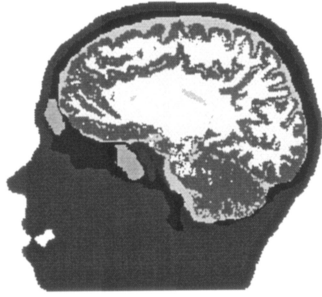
Sagittal slice of the segmented MRI data. In the slice are shown the segmented scalp, skull, and brain. Nonsegmented tissues are put together with scalp, and they do not contribute much to the signal in typical imaging setups. Also shown in the slice are two sinuses (empty spaces inside the bone of the skull).
